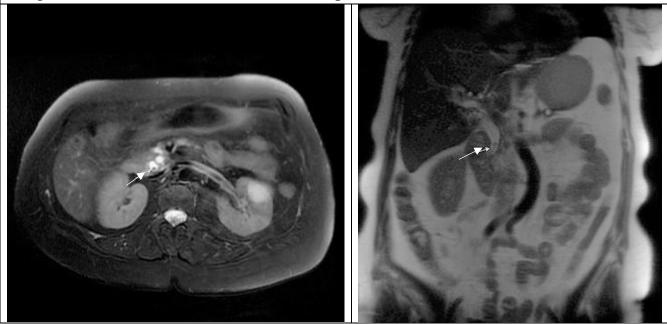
MRI – Patient after ERCP; LC; clip and stone
